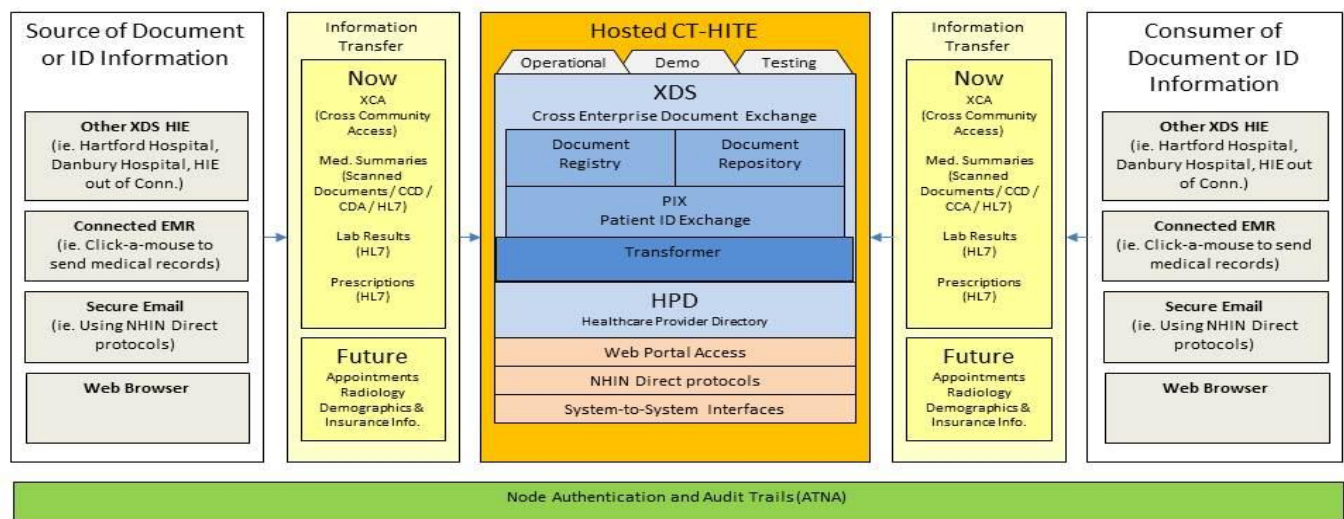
HITE-CT System Services Capabilities
